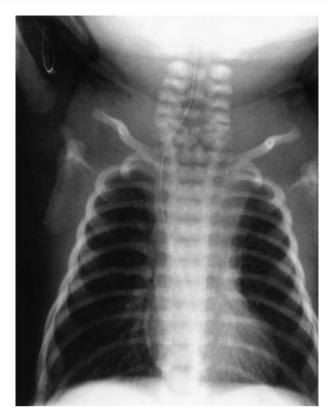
Neurenteric cyst. The presence of a cleft vertebral anomaly underlying a rounded mass indenting the upper trachea and deviating to the right, as seen in this chest radiograph, is characteristic of a neurenteric cyst.
